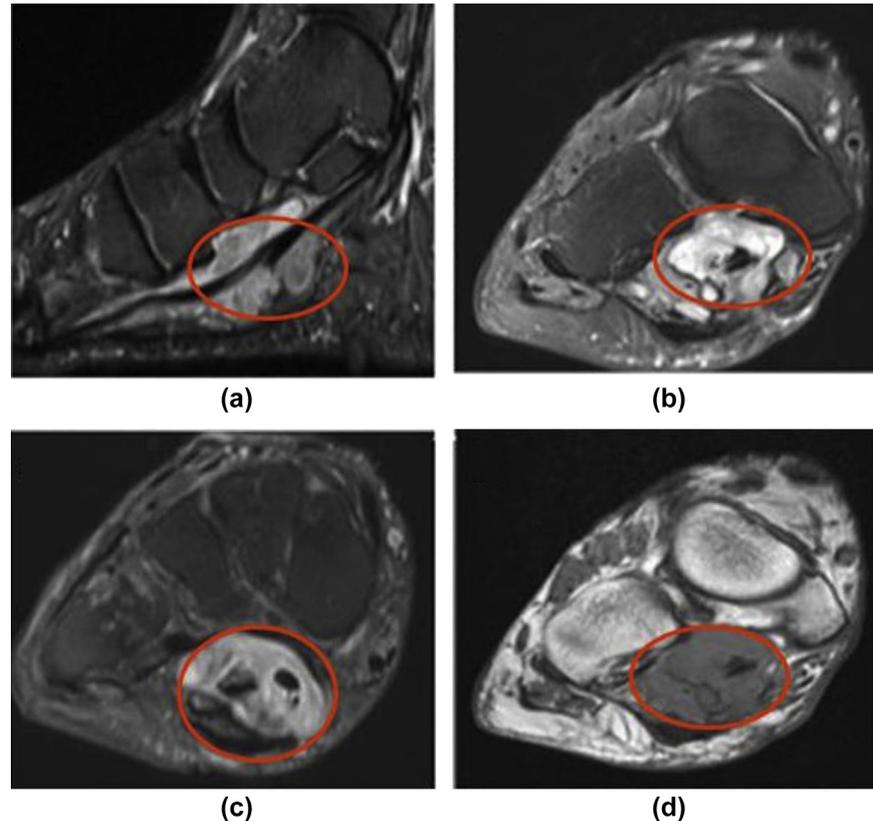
(a) STIR sagittal, (b) STIR coronal, (c) STIR coronal, (d) T1 coronal MRI images show a lobulate lesion with low T1 and high heterogeneous FS signal within the knot of Henry. Curvilinear projections are seen within the lesion. Note that the FS signal is not as homogeneous as in the previous simple myxoid lesion and the borders are slightly less well defined. Pathology from wide surgical excision revealed myxofibrosarcoma.
